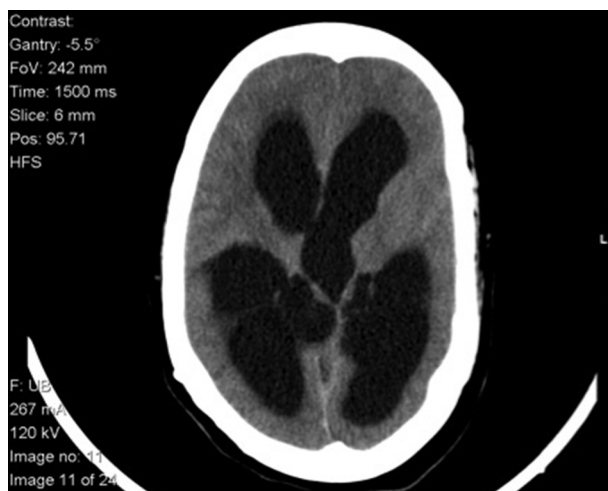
Admission CT scan showing triventricular hydrocephalus.
